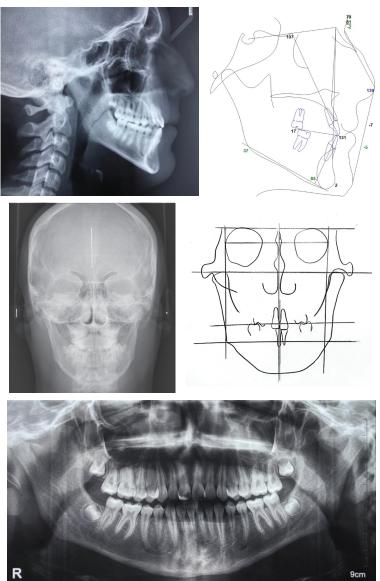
X-ray images of the lateral, anteroposterior, and panoramic views before treatment.
